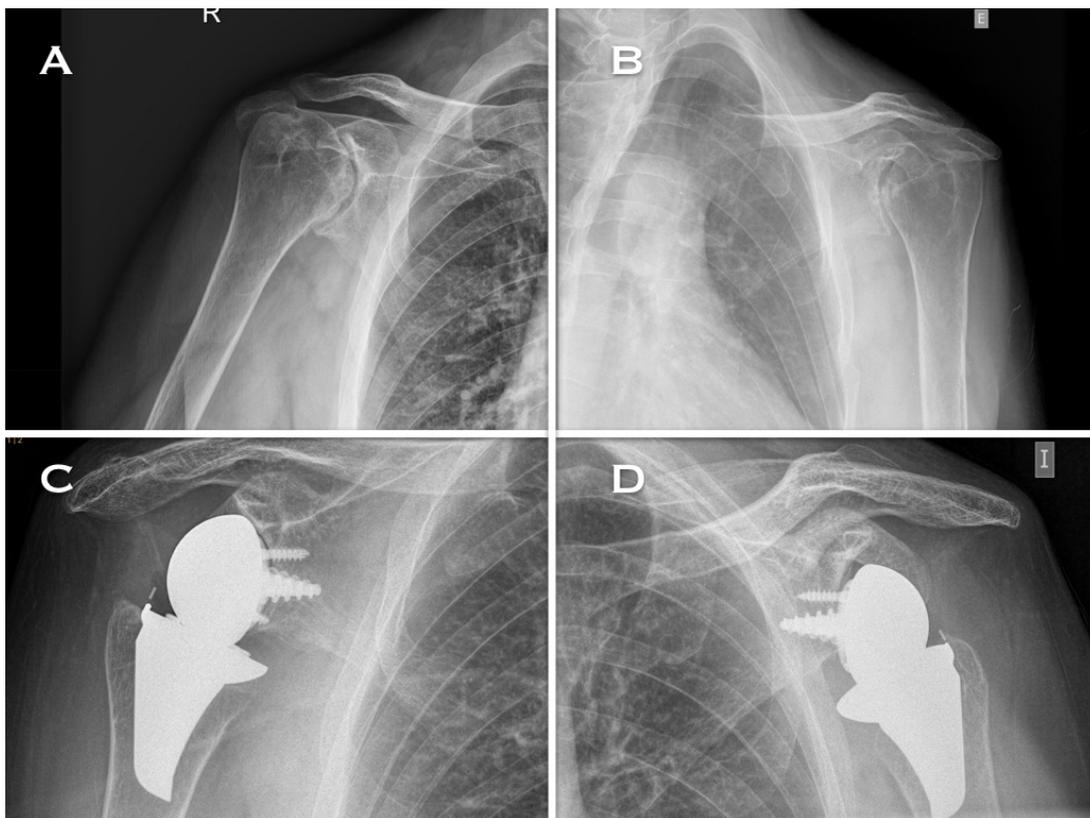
X-rays of both shoulders of a 46 years-old gentleman with history of psoriatic arthritis, who had undergone bilateral stemless reverse total shoulder arthroplasty with the Verso. The left shoulder was operated when the patient was 45 years-old, and the right one was operated 15 months after.
